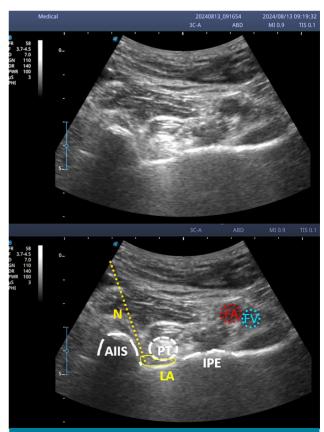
Ultrasound guided PENG block. AllS: Anterior inferior iliac spine; FA: Femoral artery; FV: Femoral vein; IPE: Iliopubic eminence; LA: Local anesthetic patch; N: Needle; PT: Psoas tendon; PENG: Pericapsular nerve group block.
